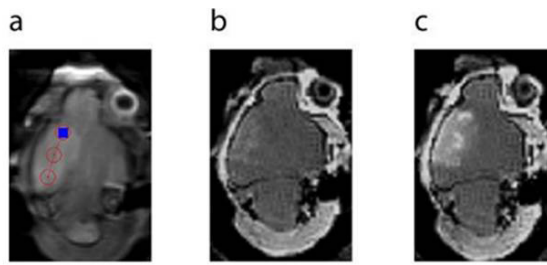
A: T2 MRI post-stroke. B: Red circles = treatment plan. B: Pre-FUS contrast MRI. C: Post-FUS contrast MRI.
